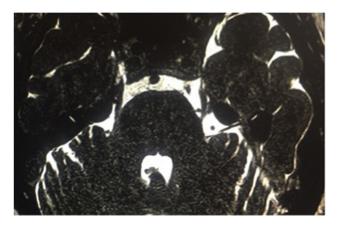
MRI imaging (T2-CISS) showing a left-sided neuro-vascular compression of the trigeminal nerve by the SCA.
